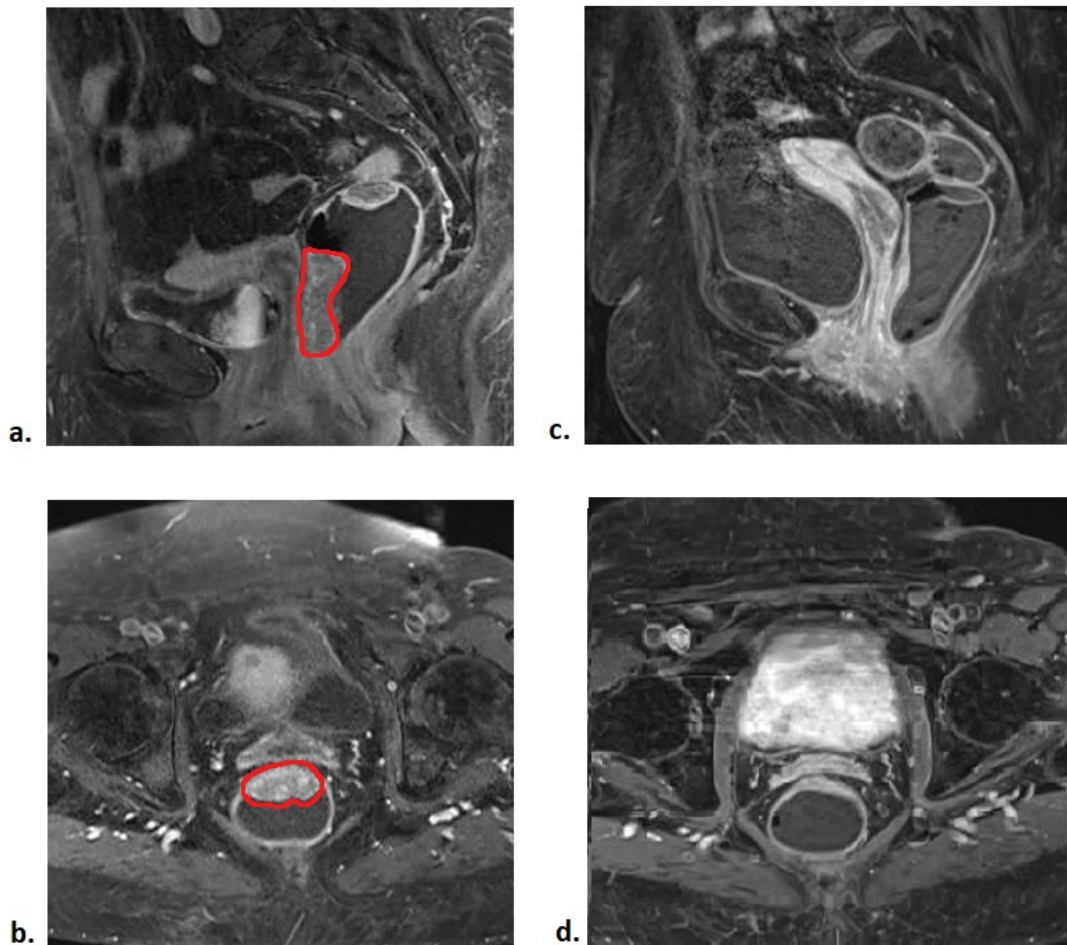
Diagnostic pelvic MR images in sagittal and transversal view, at the time of diagnose (a and b) and three months after treatment (c and d). In red the gross tumor volume (GTV) in the pre-treatment MRI scan.
